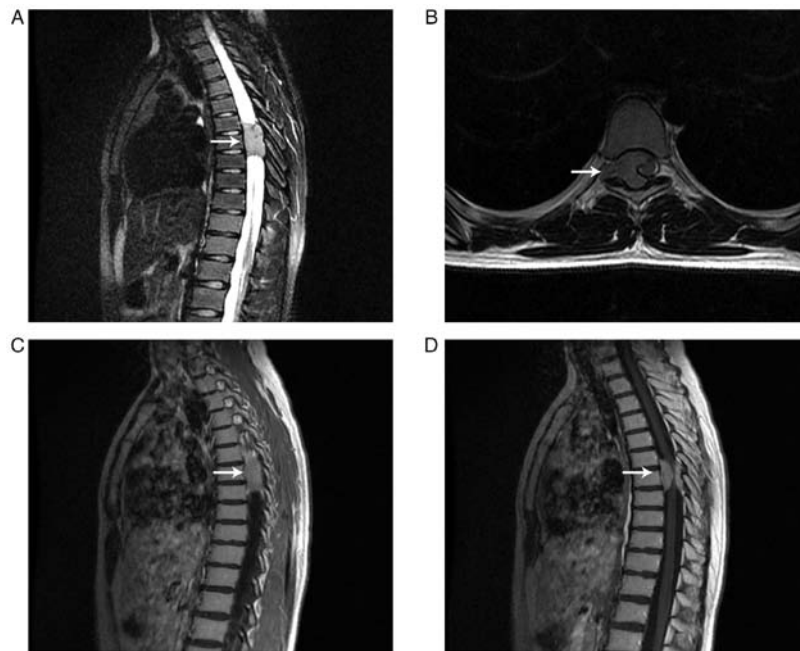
MRI examination of an oval mass in the T6-8 spinal canal (white arrows). (A) T2-weighted image showed mass from median sagittal section. (B) T2-weighted image demonstrated that the tumor grew out of the spinal canal through the intervertebral foramen from transverse sections. (C) T1-weighted image demonstrated an indistinct tumor boundary. (D) T1-weighted image demonstrated that the spinal cord was significantly compressed and displaced to the left side.
